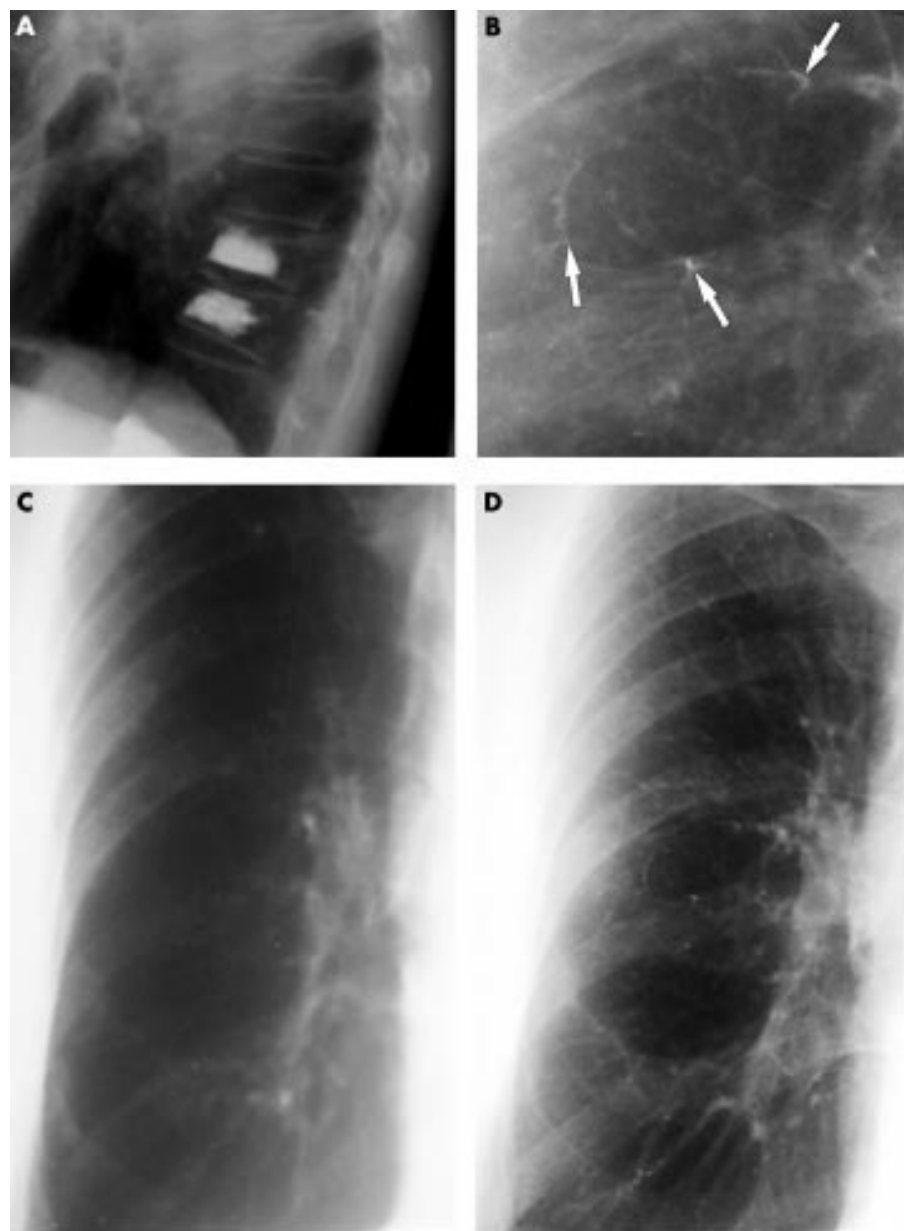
(A) Six months after vertebroplasties the chest radiographs show radiodense cement in the fractured vertebral bodies T10, T11, and L1. (C and D) Posteroanterior views of the right lung. The pulmonary arterial vessels look normal before the vertebroplasties (C). In contrast, multiple radiodense lines along the pulmonary vessels are detectable thereafter. (B) Shows a more detailed view of (D). Three of the cement emboli are marked with white arrows.
